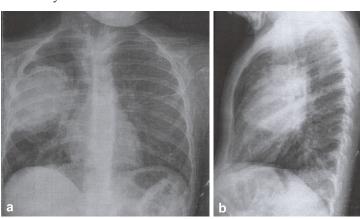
Chest X-ray revealing reduction of the tumor volume after chemotherapy.
